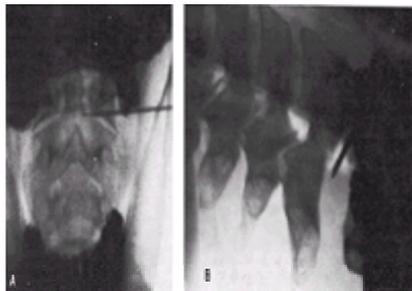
Position of needle electrode for percutaneous C-1 to C-2 cordotomy as seen on anteroposterior (A) and lateral (B) radiographs.
